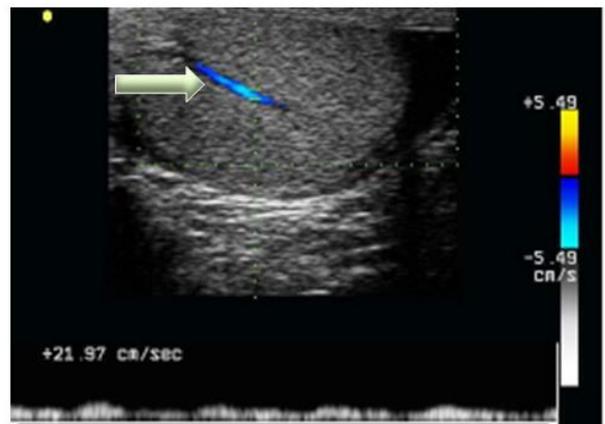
b: Doppler study shows colour flow in the linear structure traversing the testis (Colour doppler image)
